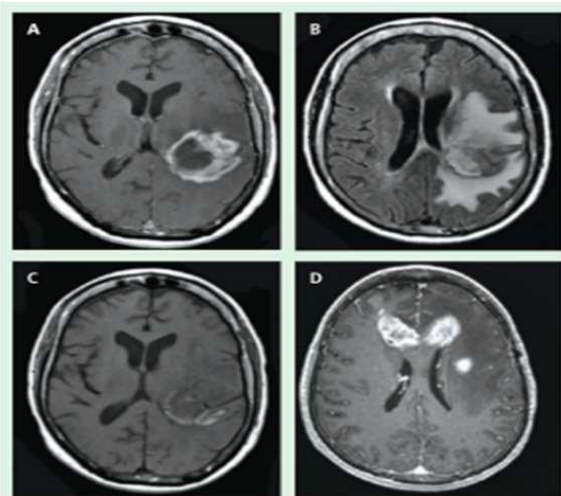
Radiographic Features of Glioblastoma on Magnetic Resonance Imaging.<sup>2</sup>
